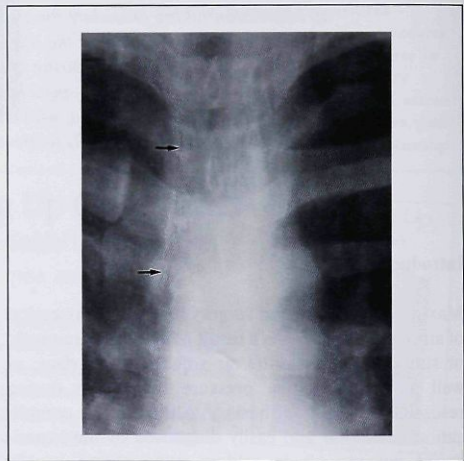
Detail of a posteroanterior chest radiograph, revealing paratracheal air dissection extending to the mediastinum (arrow).
